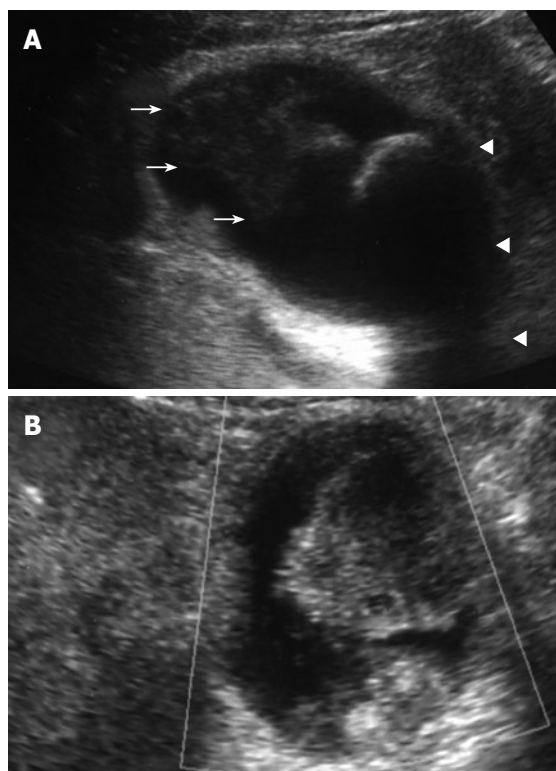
Plain US. (A) of the GB showing wall thickening of the neck and body (consistent with cholecystitis), a strong echoic level with acoustic shadow at the neck (consistent with stones), and a mass-like lesion of the fundus, and Doppler US (B) revealing no blood flow in the mass-like lesion.
